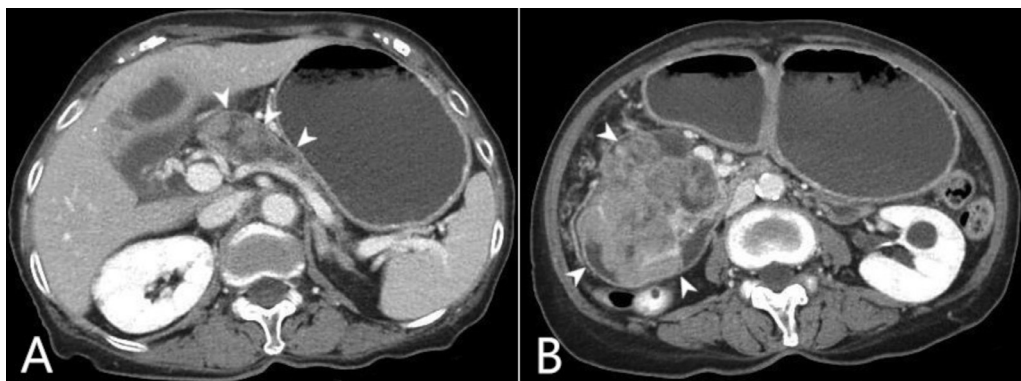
Contrast-enhanced axial computed tomography scans. (A) Mild-enhancing papillary nodules were observed in the dilated main pancreatic duct. Severe atrophic changes were observed in the pancreatic parenchyma. (B) A heterogeneous enhancing lobulated contoured mass of 8 cm was seen in the second portion of the duodenum.
